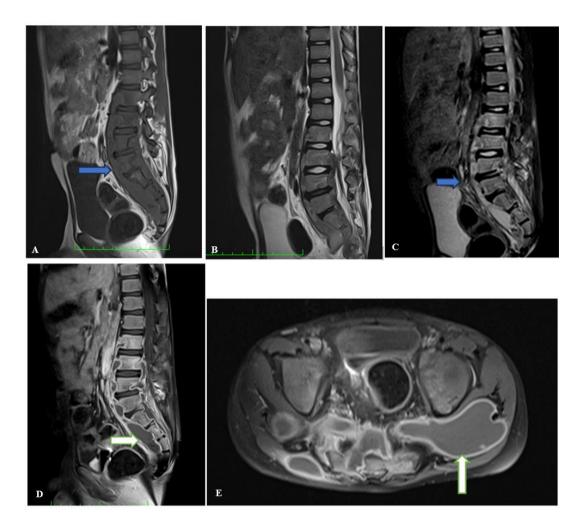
Tuberculous spondylitis in a 45 year old male (A) T1-weighted sagittal image (B) T2-weighted sagittal image (C) Sagittal STIR image show heterogeneous abnormal signal intensity from L2-S2 vertebrae; also note large epidural extension and subligamentous spreading from L2 – S3 level (blue arrow). Preservation discs is seen.
